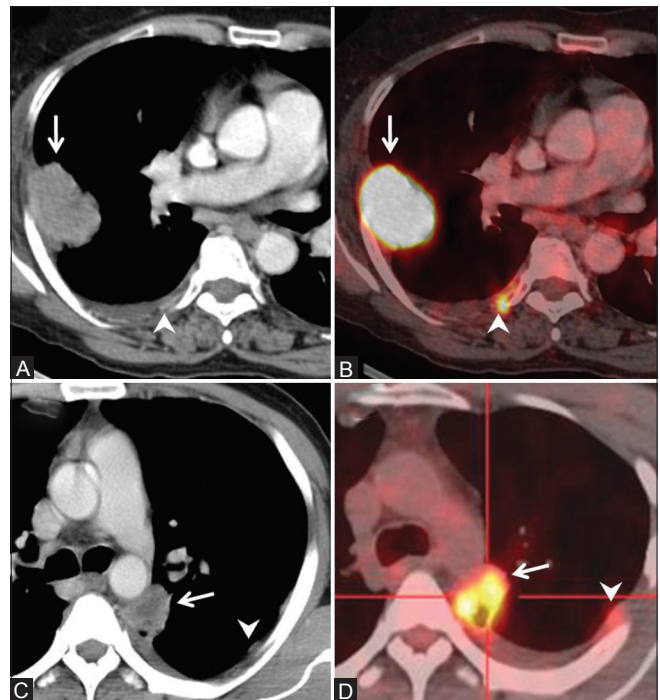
(A-D): Pleural effusion and role of FDG PET/CT. Enhancing lung masses seen on CT scans in two different patients (arrows in A and C) with minimal pleural effusions (arrowheads in A and C). Corresponding PET/CT scans show intense FDG-avid metastatic pleural deposits (arrowheads in B and D) as the cause of effusions. Note that the pleural deposits are barely perceptible on CT
